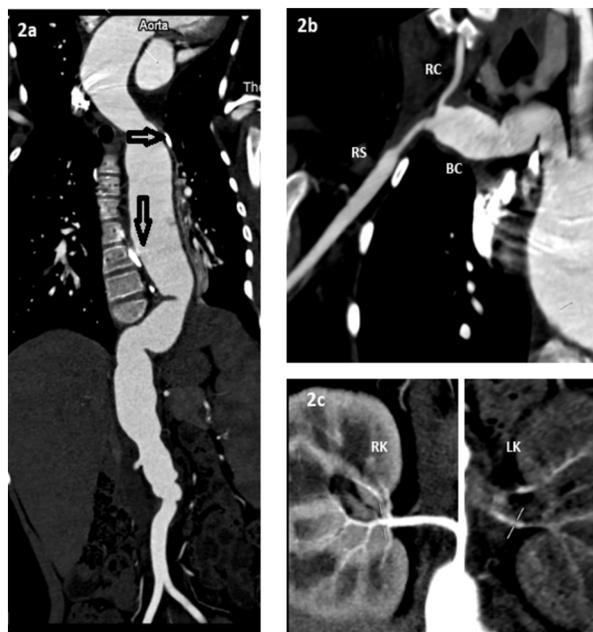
Computed tomographic angiography (curved multiplanar reconstructions) demonstrating (a) dilated, tortuous aorta with areas of stenosis, irregularity of wall and calcific foci (arrows) along wall; (b) dilated and tortuous brachiocephalic artery (BC) with narrowed proximal segments in right subclavian (RS) and right common carotid (RC) arteries, and (c) attenuated left renal artery.
